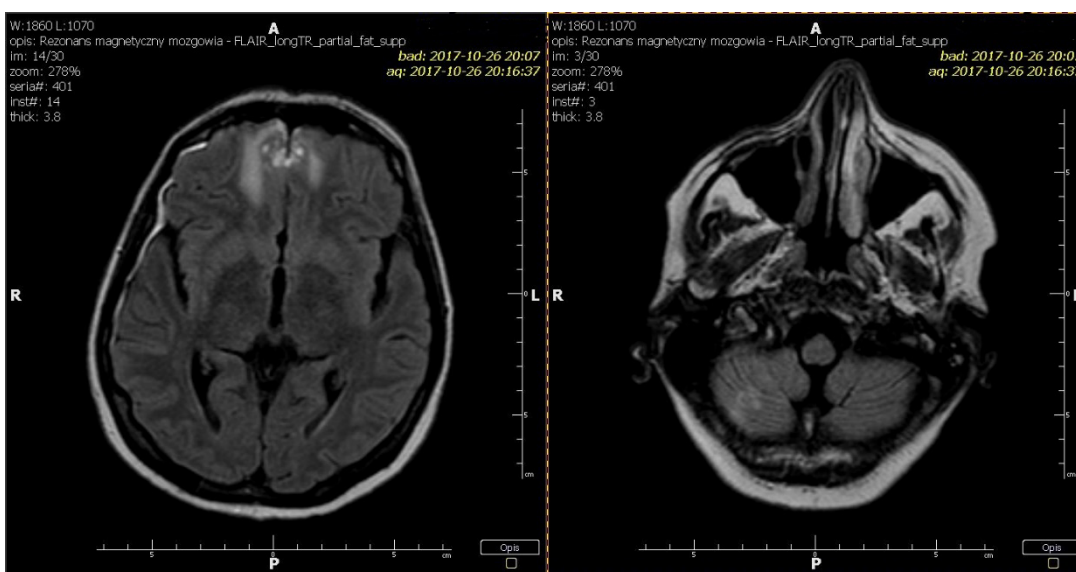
A MRI of the patient's brain
